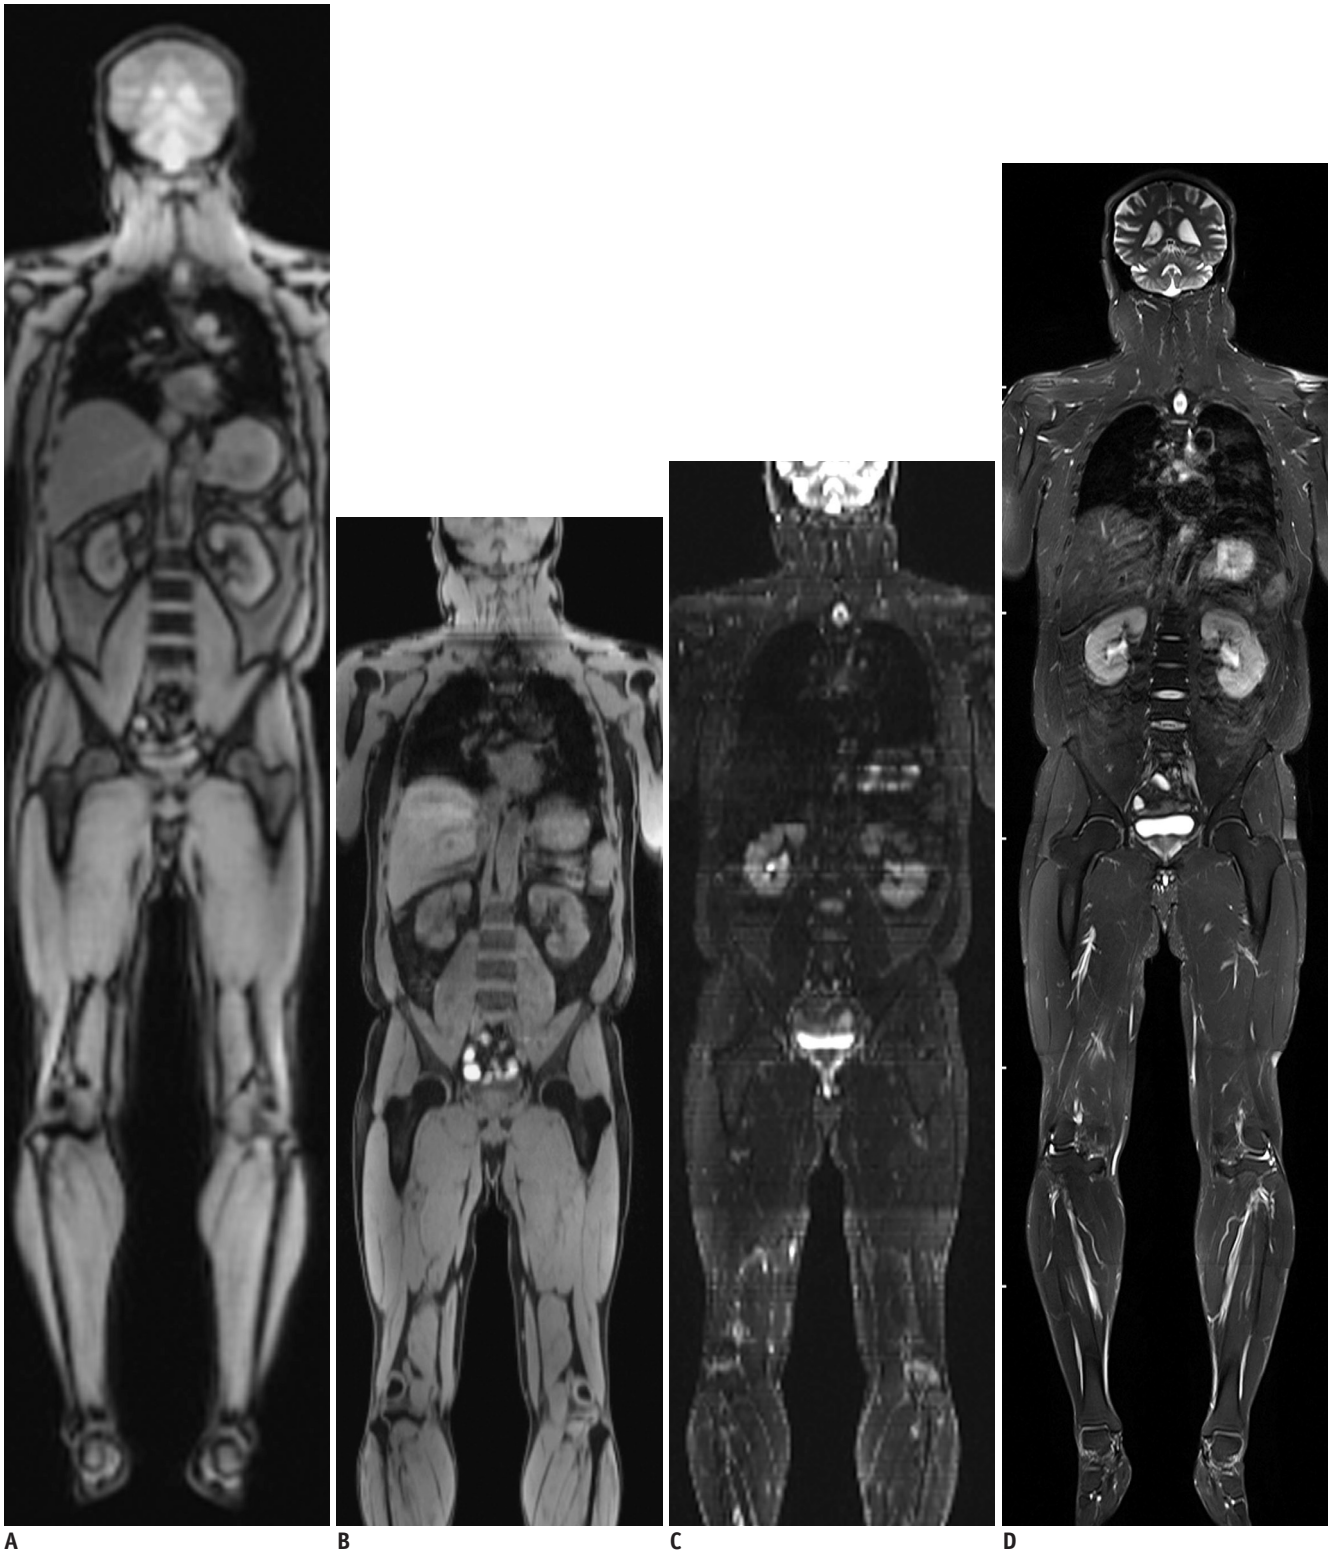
Whole-body magnetic resonance imaging (MRI) using continuously moving table approach in adult volunteer.
